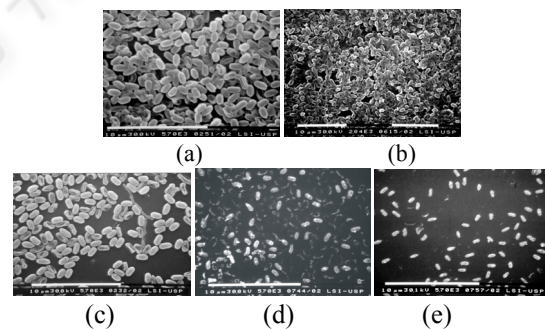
(a) Sample before the processes; (b) Sample after the UV process; (c) Sample after the X-ray process; (d) Samples after the plasma process with 100 W of power; (e) Sample after the plasma process with 150 W.
